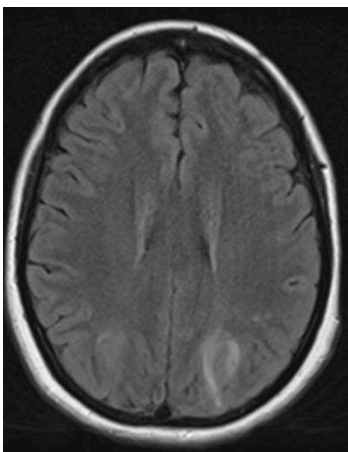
(above): MRI brain showing features of PRES with FLAIR hyperintensity demonstrated in the bilateral parietal occipital lobes
